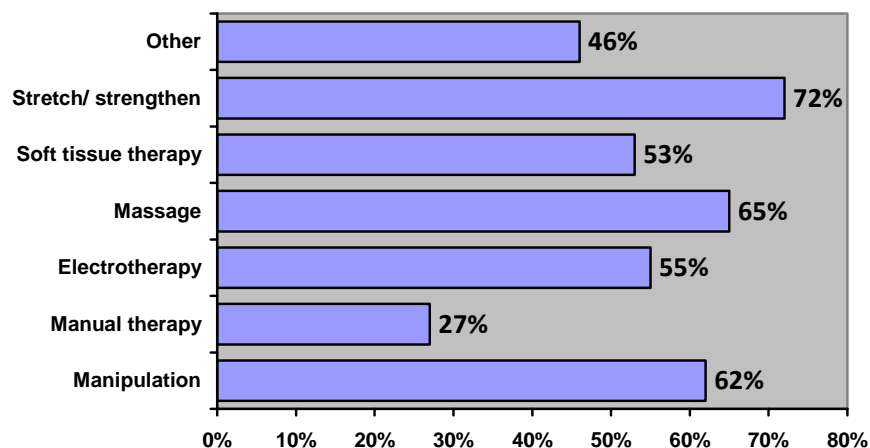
Management of the patients after lumbar spine x-rays were obtained
